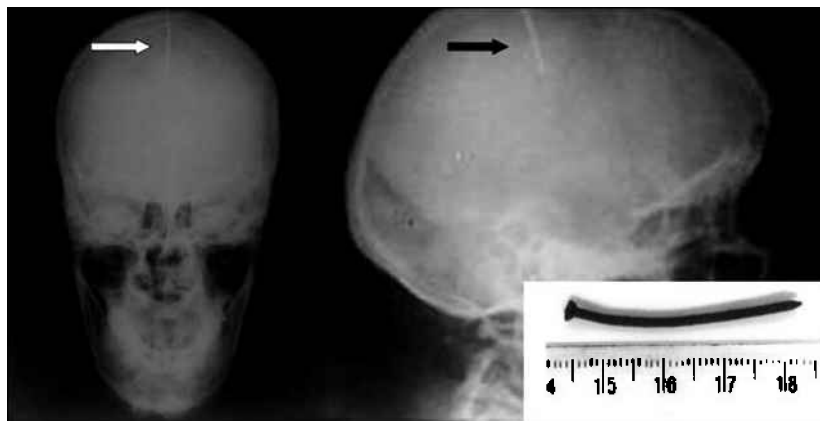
Skull radiographs taken in the anteroposterior (left) and lateral (right) projections show the nail (arrow) very close to the right side of the midline. Inset photograph shows the removed nail.
